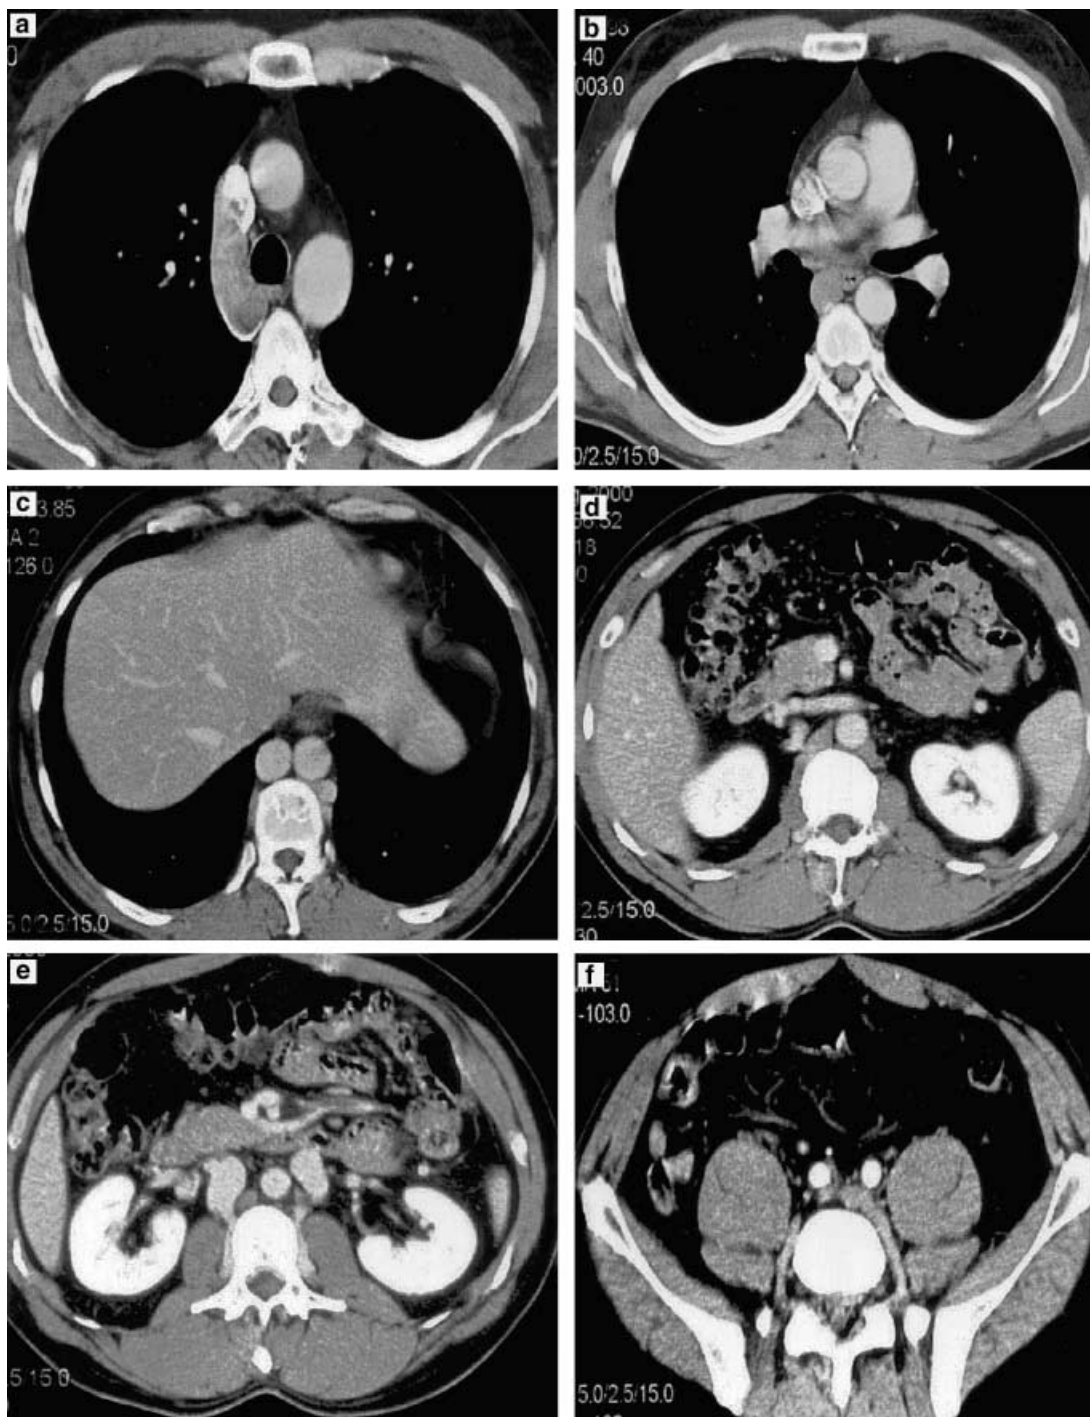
CT at the level of the upper (a) and middle (b) third of the thorax, the azygos vein is enlarged that at conventional plain film radiography of the thorax had been suspected to be lymphoma. CT at the level of the lower third of the thorax (c), the azygos vein is well enlarged and approximately has the same diameter as the aorta. On the left hand side the hemiazygos vein is enlarged as well. A vena cava inferior is not visible and hepatic veins are draining into the azygos vein (not demonstrated here). CT at the level of the right renal vein draining into retroperitoneal collateral veins (d) because of absence of the vena cava inferior. CT at the level of the hilum of the kidneys; right and left descending vena cava (e) inferior in the infrarenal portion. CT at the level of the pelvis, the common pelvic arteries are well visualized. There is no right or left pelvic vein and the drainage of the venous blood is accomplished by enlarged perilsacral/perisacral veins (f).
